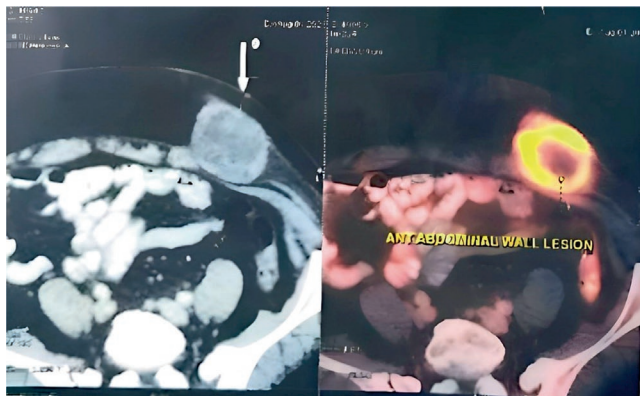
CECT abdomen showing well-defined oval hypodense lesion of size 5.3 × 5.2 × 4.2 cm seen in deep subcutaneous plane of anterior abdominal wall with maintained fat plane. (b) FDG avid heterogeneously enhancing soft tissue mass with central necrosis.
